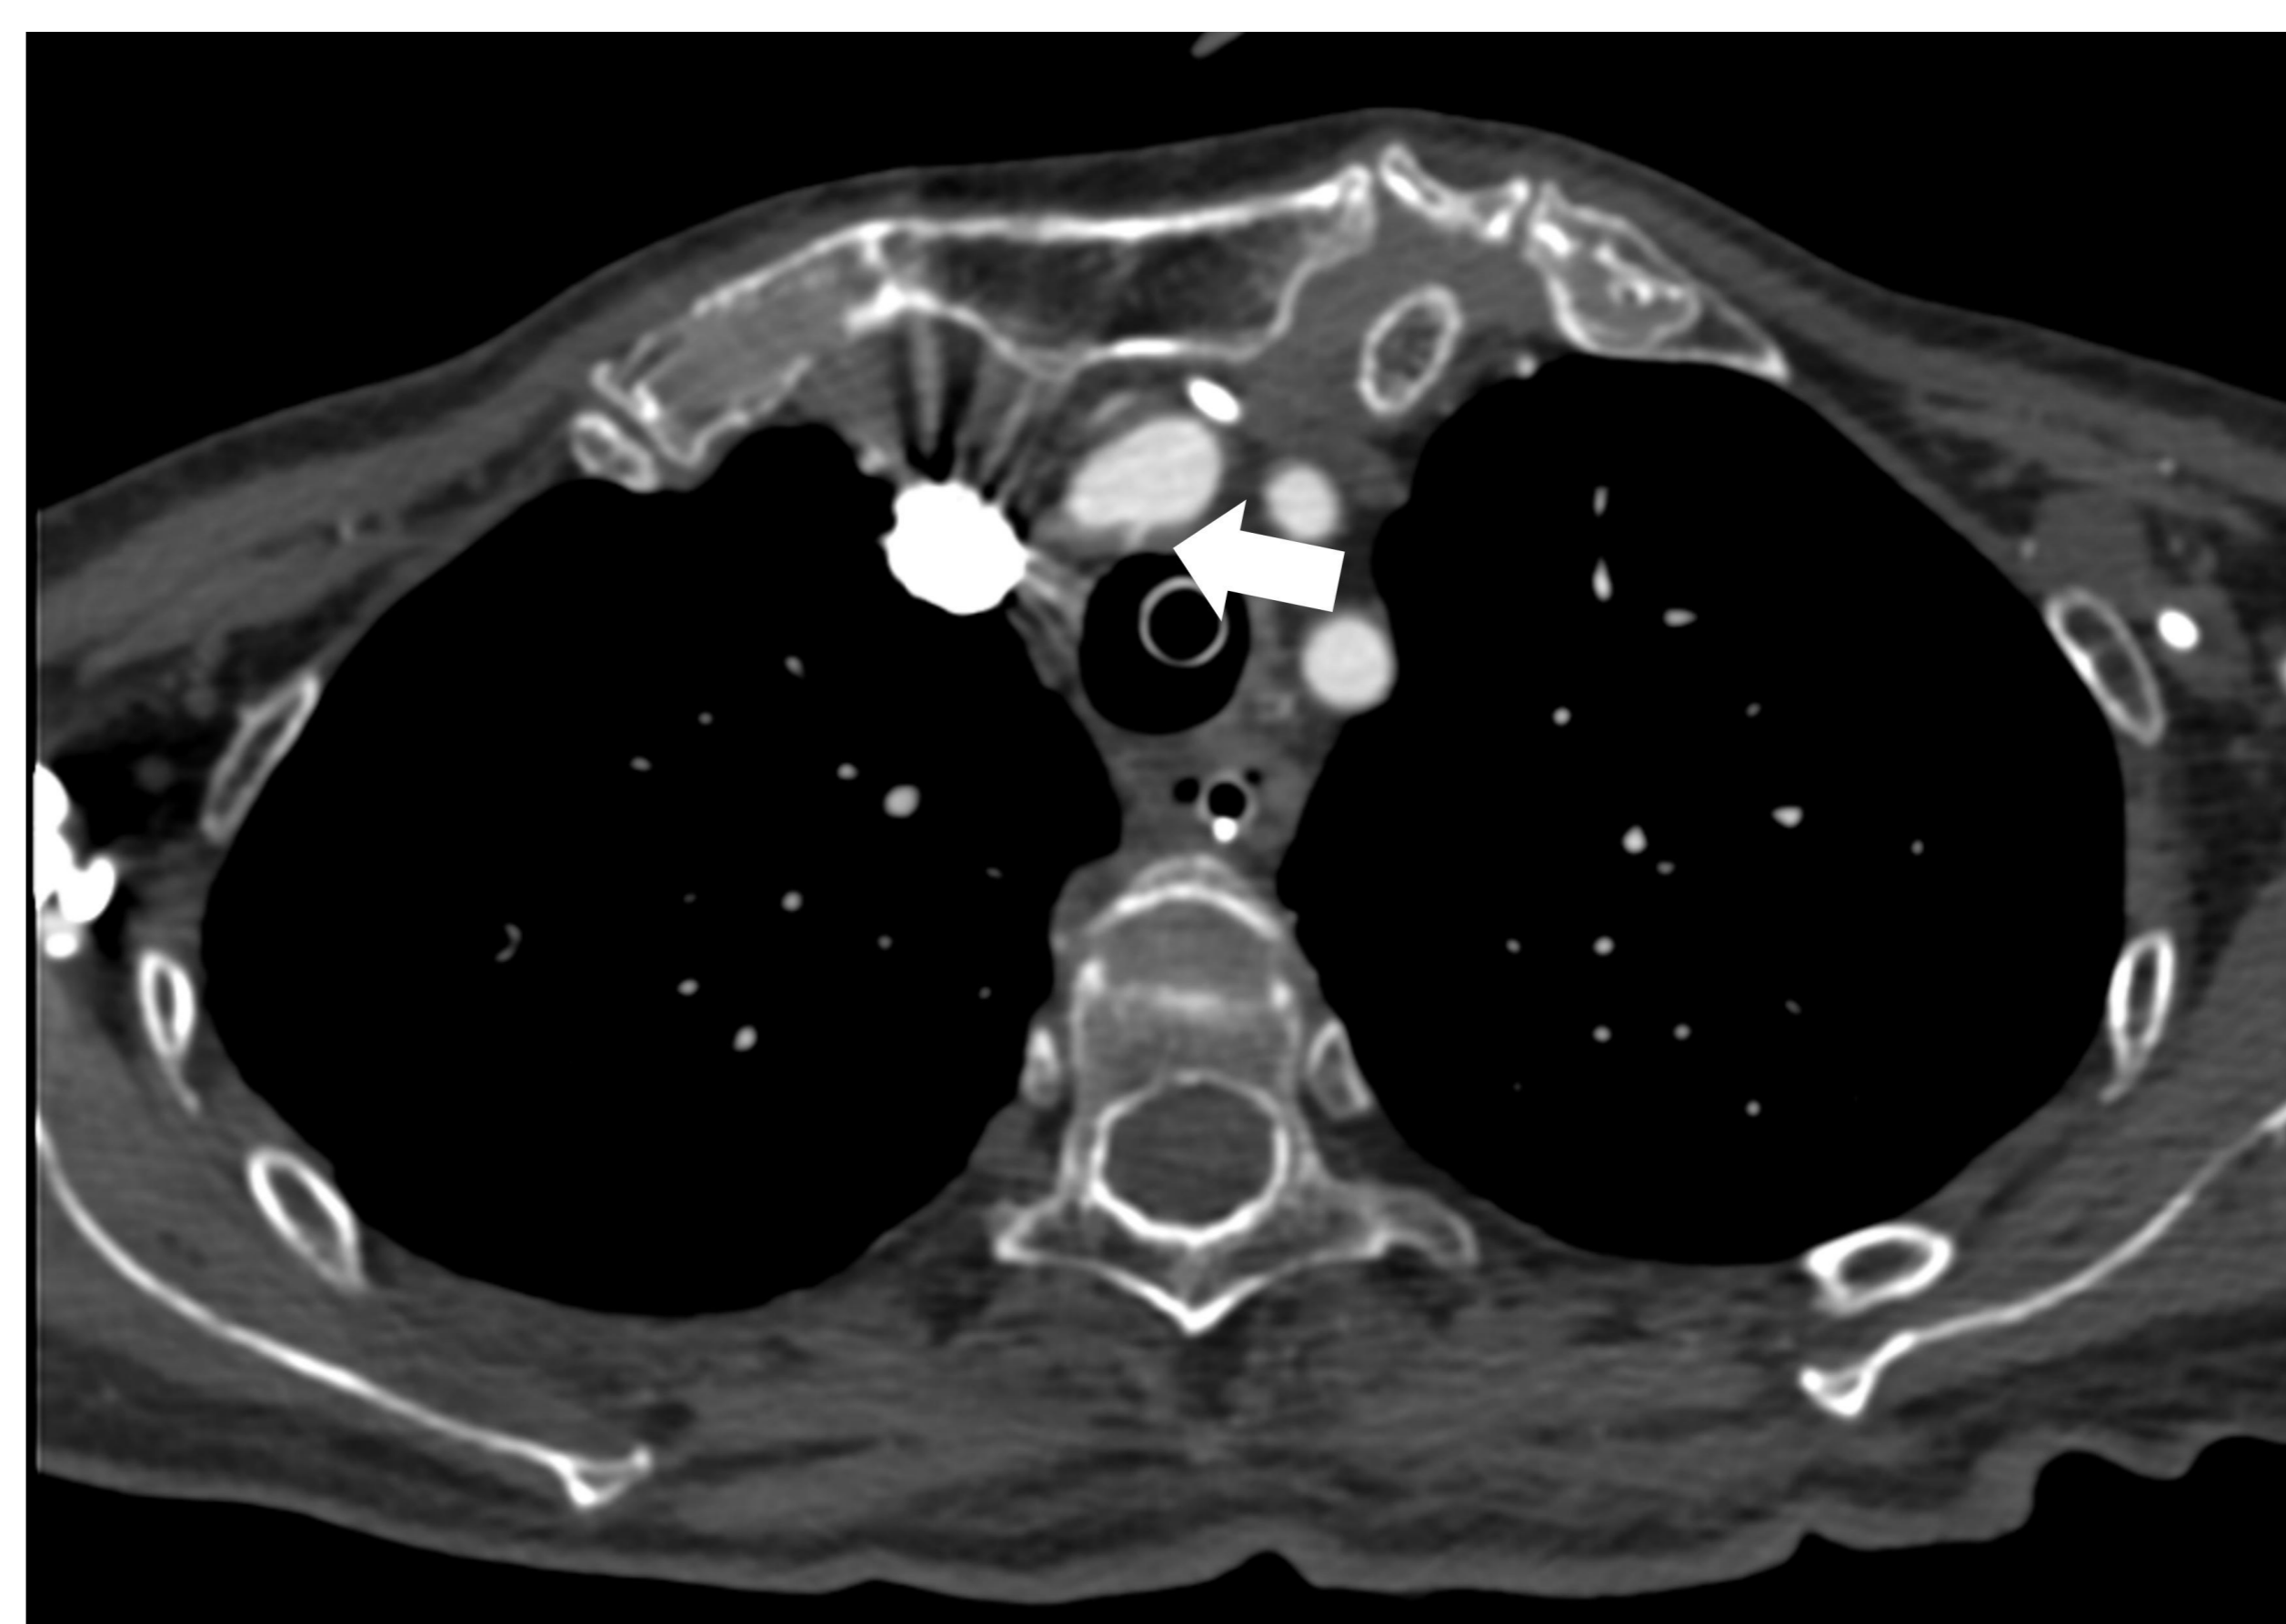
Contrast-enhanced chest CT scan showing a tracheoinnominate artery fistula (arrow).
